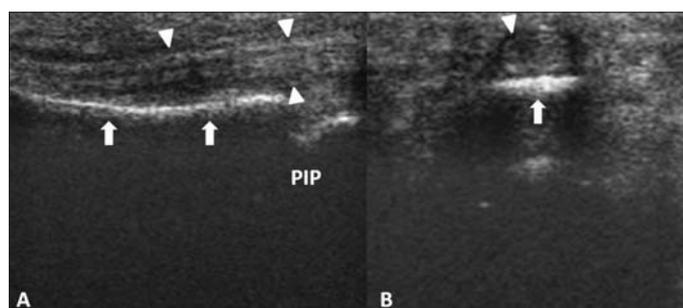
Sonographic imaging of the second finger at the level of the midphalanx (white arrows) (A) Longitudinal and (B) Axial views demonstrate the hyperechoic flexor tendon (white arrow heads). PIP: Proximal interphalangeal joint.
